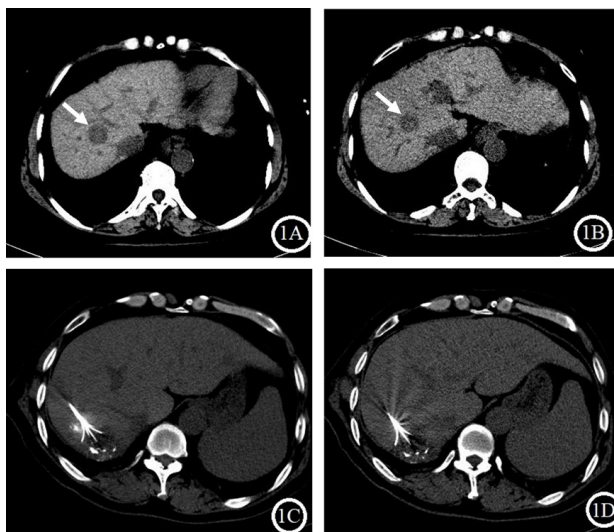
The CT images of liver under different conditions. A: Image of liver at regular dose; B: Image of liver at low dose; hepatic mass was arrowed. C: The needle electrode is shown in a liver mass at conventional dose; D: The needle electrode at low dose.
